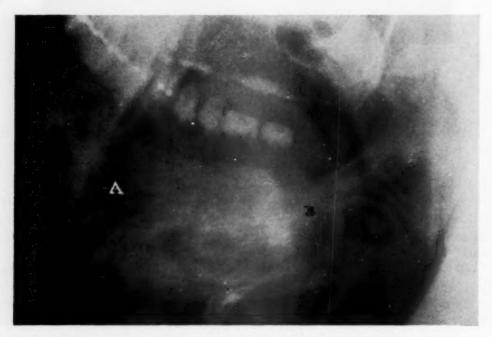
Postoperative x-rays showing site of biopsy, A, and extraction wound, B.
